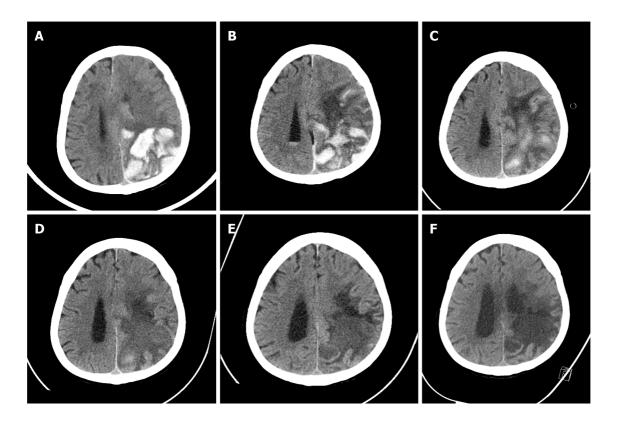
Change in brain computed tomography during hospitalization. A: Brain computed tomography (CT) at admission. Intracranial hemorrhage in the parieto-occipital lobe was confirmed, and midline shift was observed due to brain edema; B: Brain CT on the 8th hospital day. Intracranial hemorrhage persists and concomitant Intra-ventricular hemorrhage (IVH) is confirmed; C: Brain CT on the 17th hospital day. Intracranial hemorrhage has begun to resolve and improvement of IVH is shown; D: Brain CT on the 28th hospital day. Intracranial hemorrhage shows ongoing resolution, and brain edema has also decreased; E: Brain CT on the 57th hospital day. Improvement in brain edema has resulted in dilatation of the ventricle and resolution of midline shift; F: Brain CT on the 82<sup>nd</sup> hospital day. Encephalomalacic change in the left parietal lobe is confirmed, and there is no evidence of new intracranial hemorrhage.
